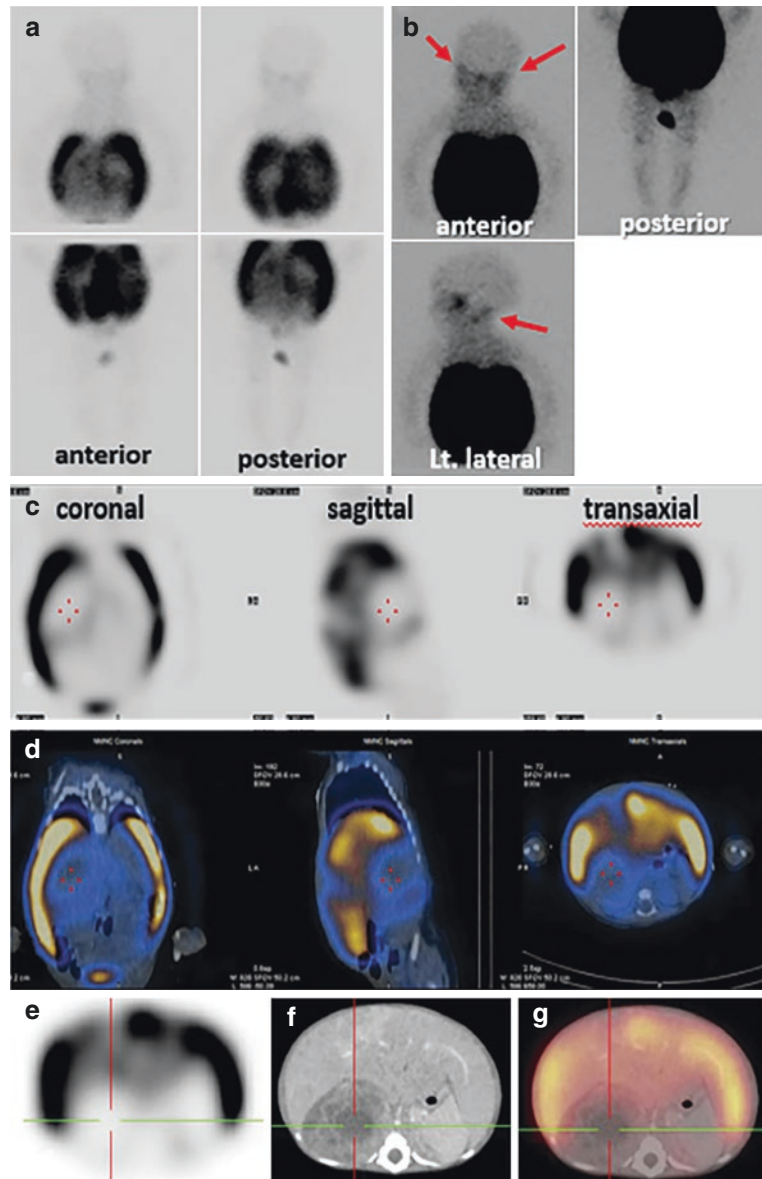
A follow-up ¹²³I-MIBG scan was obtained 2 months after the start of treatment according to the therapy protocol. Study report: MIBG scintigraphy, anterior, and posterior planar spot views of the whole body, (a) show normal tracer distribution with a resolution of the uptake in the abdominal tumor and in the metastatic sites.
